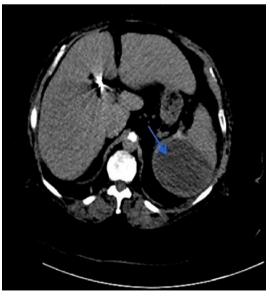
CT scan of the abdomen and pelvis without contrast showing hypodensity in the superior aspect of the spleen: transverse section.
